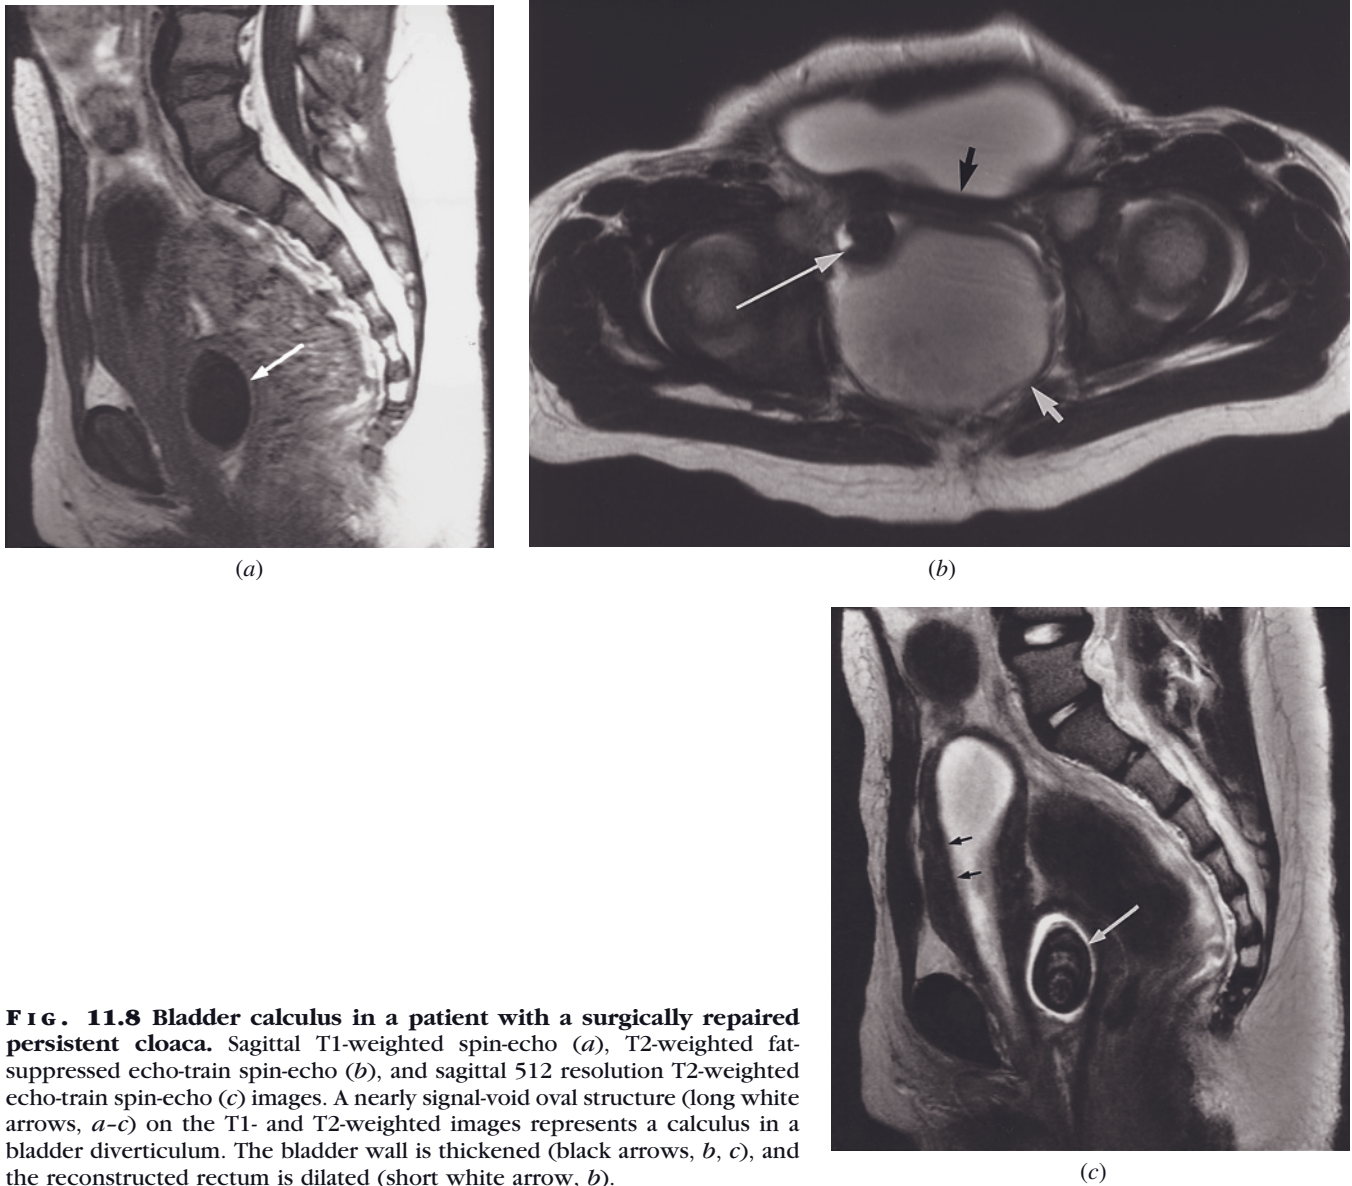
Bladder calculus in a patient with a surgically repaired persistent cloaca. Sagittal T1-weighted spin-echo (*a*), T2-weighted fat-suppressed echo-train spin-echo (*b*), and sagittal 512 resolution T2-weighted echo-train spin-echo (*c*) images. A nearly signal-void oval structure (long white arrows, *a-c*) on the T1- and T2-weighted images represents a calculus in a bladder diverticulum. The bladder wall is thickened (black arrows, *b, c*), and the reconstructed rectum is dilated (short white arrow, *b*).
